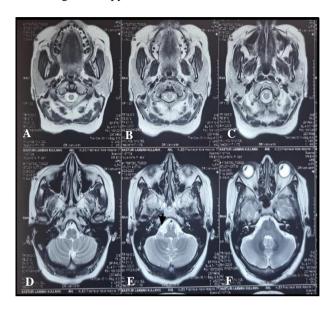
(A-F): MRI brain and inner ear suggestive of right AICA abutting the posterior aspect of vestibulocochlear nerve.
